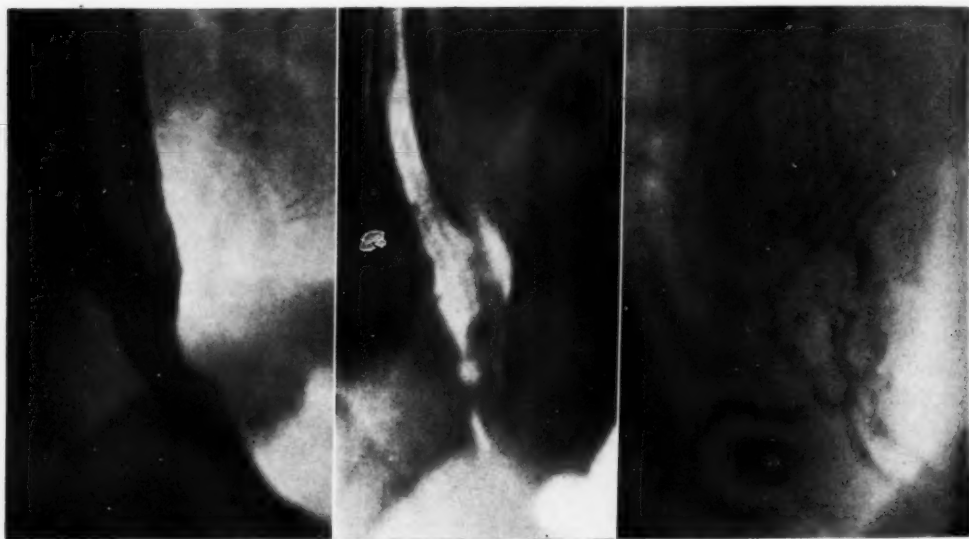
Case 1: Roentgenograms made Nov. 24, 1942 (Courtesy of Dr. F. Templeton).
